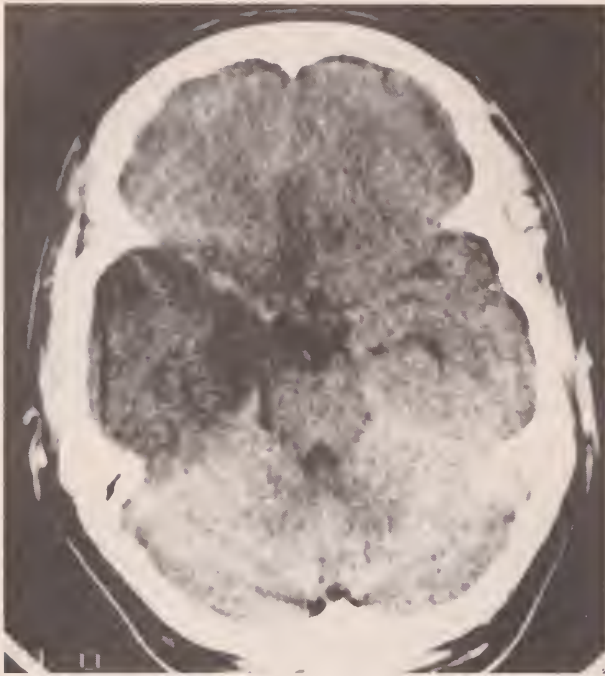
CT head scan without contrast. There is abnormal low density throughout the right temporal lobe with modest mass effect.
